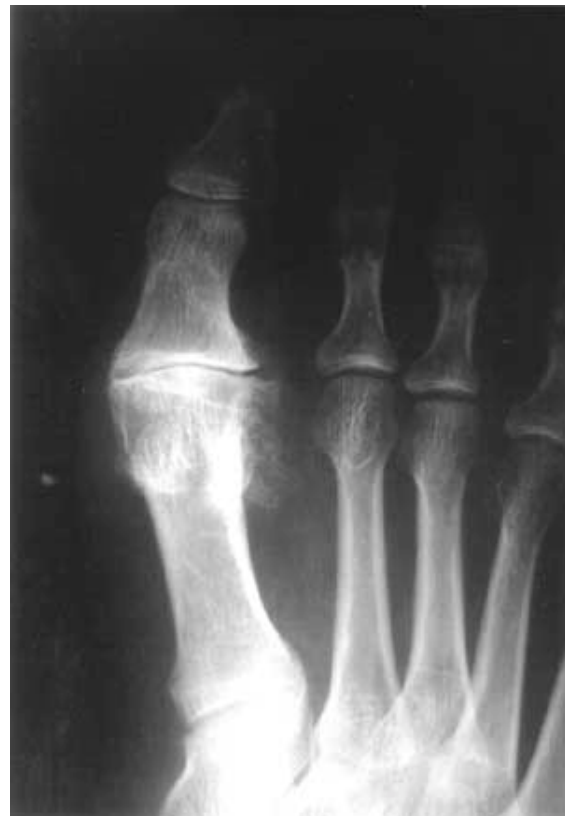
Stage II hallux rigidus: a) The dorsoplantar radiograph demonstrates joint space narrowing with osteophyte formation at the lateral and medial aspect of the first metatarsal head.
